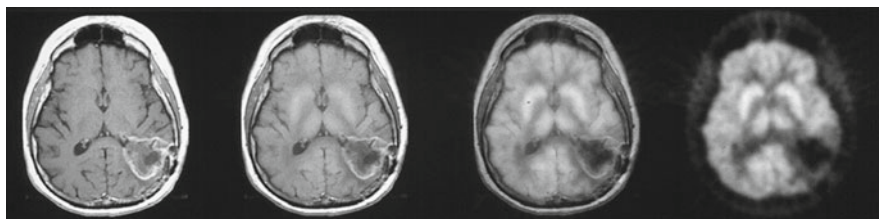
FDG PET and MRI in recurrent brain tumor
